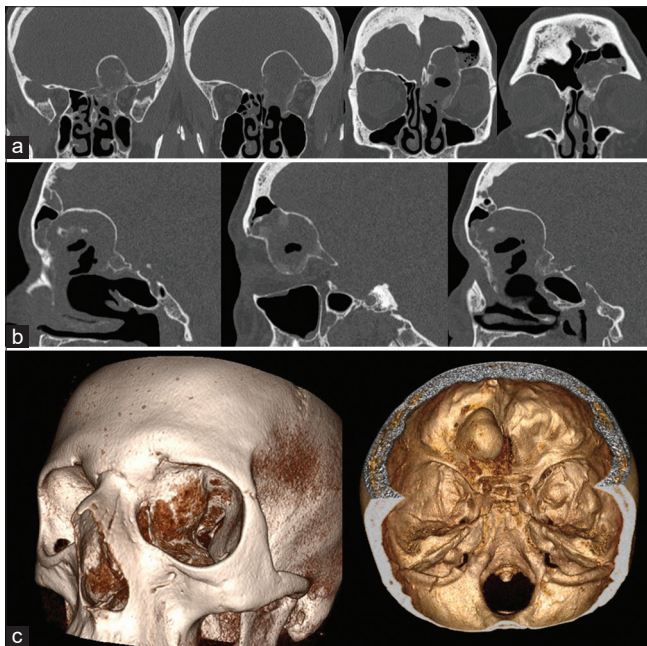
Preoperative coronal (a) and sagittal (b) head computed tomography scan images with bone algorithm and 3D-reconstruction (c) in series showing a left fronto-orbito-ethmoidal intradiploic lesion, with frontal sinus involvement.
